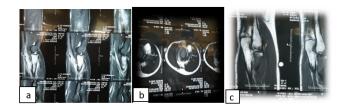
a,b,c): MRI different sections showing medullary extension of tumour with minimal soft tissue extension
